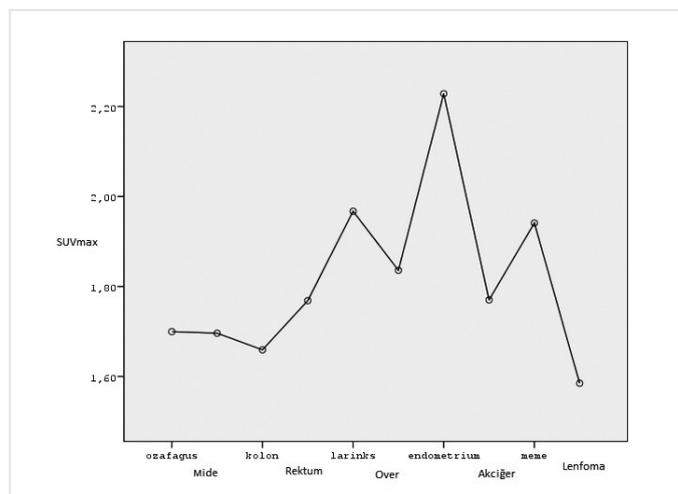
Mean SUV_{max} measurements of ROIs plotted on aortic arch according to diagnosis
